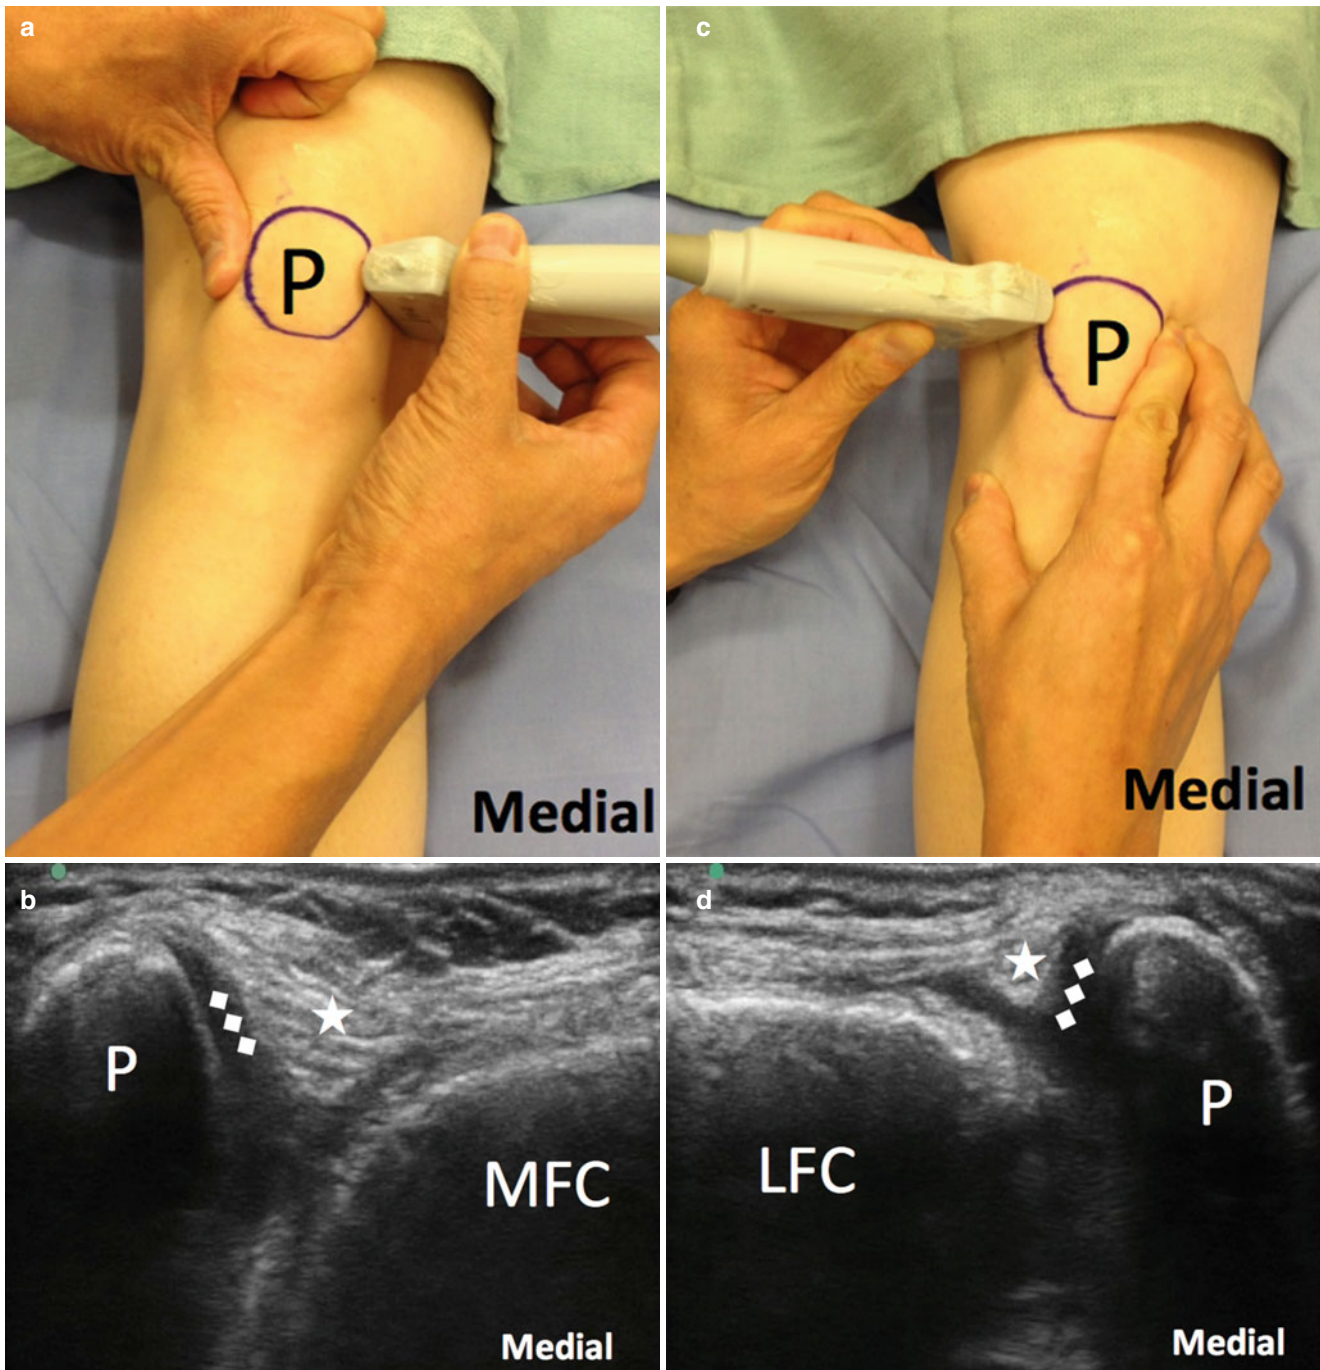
(a, c) Pictures showed the position of the ultrasound probes and the manipulation of the patella by the examiner. The patella was pushed to the medial and lateral sides respectively in (a, c). The respective sonograms (b, d) showed the medial and lateral views respectively.
